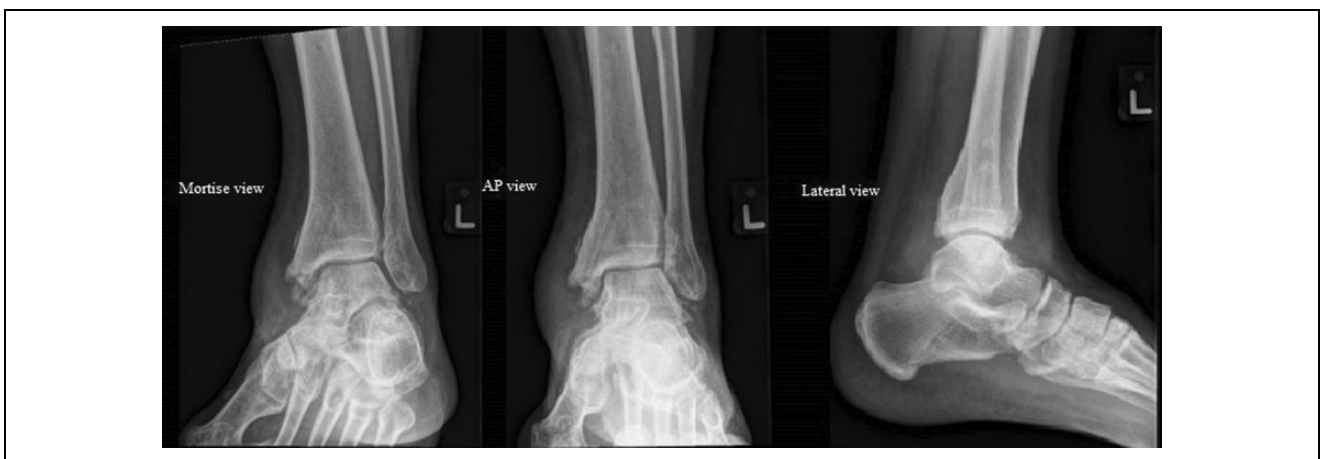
Anteroposterior/mortise/lateral radiographs of the left ankle at 22 months of follow-up.
